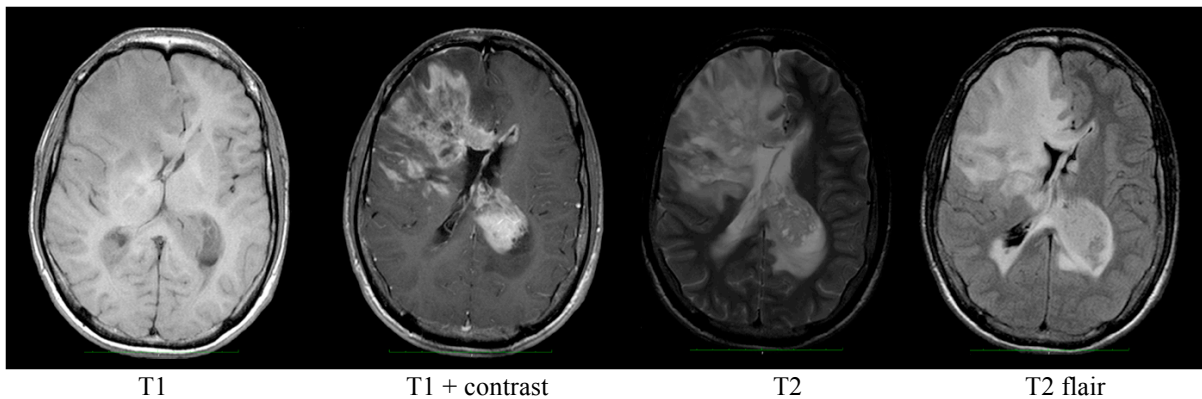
Different modalities of MR images in a single patient with glioblastoma at the time of diagnosis.
